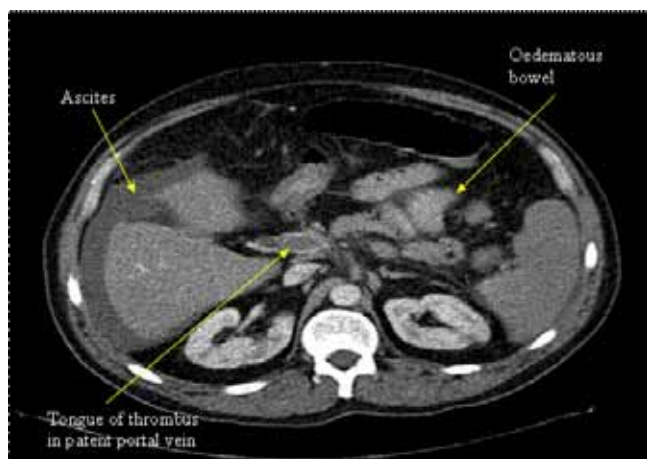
Abdominal CT showing tongue of thrombus extending into portal vein, bowel wall oedema and ascites.
